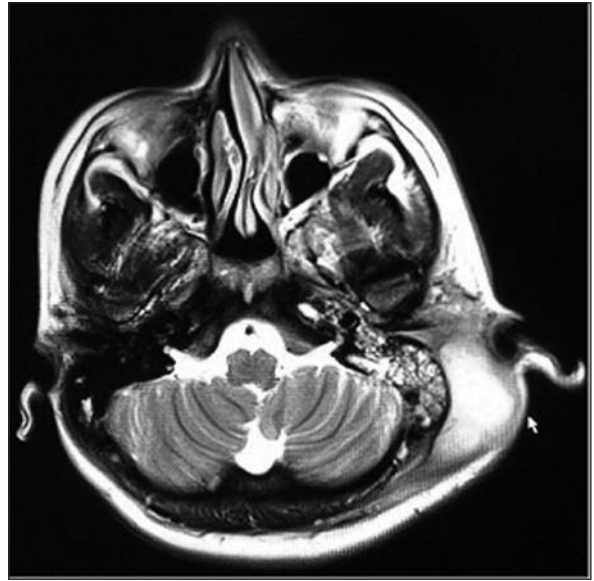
Deep tissue infection and epidural effusion were revealed in MRI.
